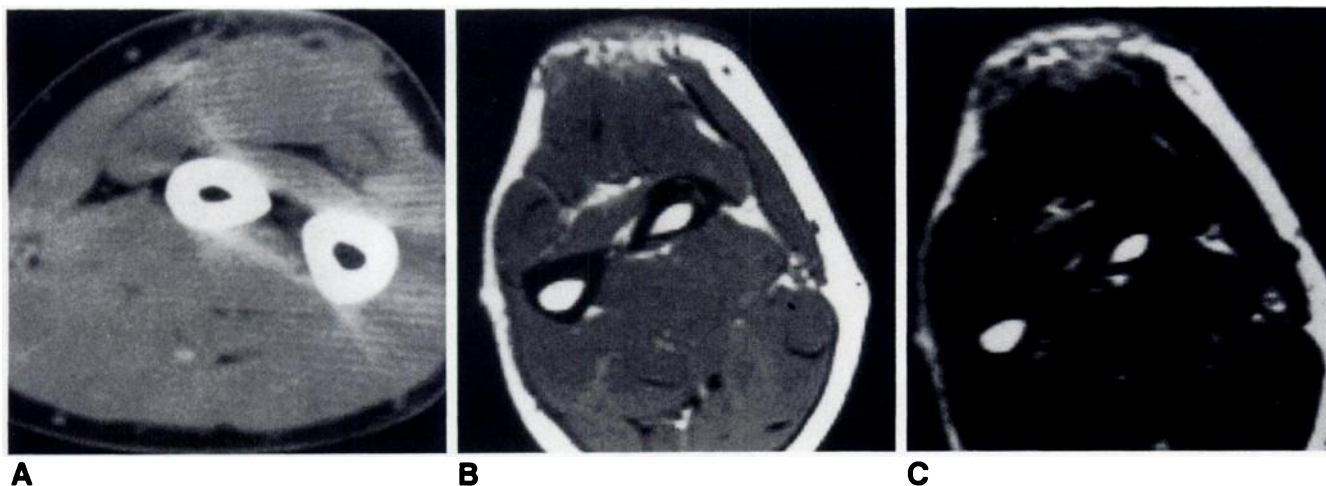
High-grade malignant fibrous histiocytoma of forearm in a 45-year-old man. A, Axial contrast-enhanced CT scan shows poorly defined soft-tissue mass infiltrating subcutaneous fat. B and C, Corresponding axial T1-weighted, 700/34, (B) and T2-weighted, 2000/80, (C) MR images show malignant fibrous histiocytoma lacks lacelike fatty pattern typically seen in hemangiomas on T1-weighted images and also lacks typical hyperintense signal seen on T2-weighted images. Lesion infiltrates subcutaneous fat and mimics many findings seen in hemangioma in Fig. 5.
